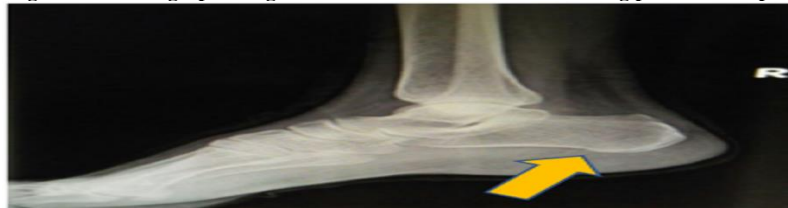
Six months old post operative plain radiograph of right ankle and foot: lateral view following spur excision
